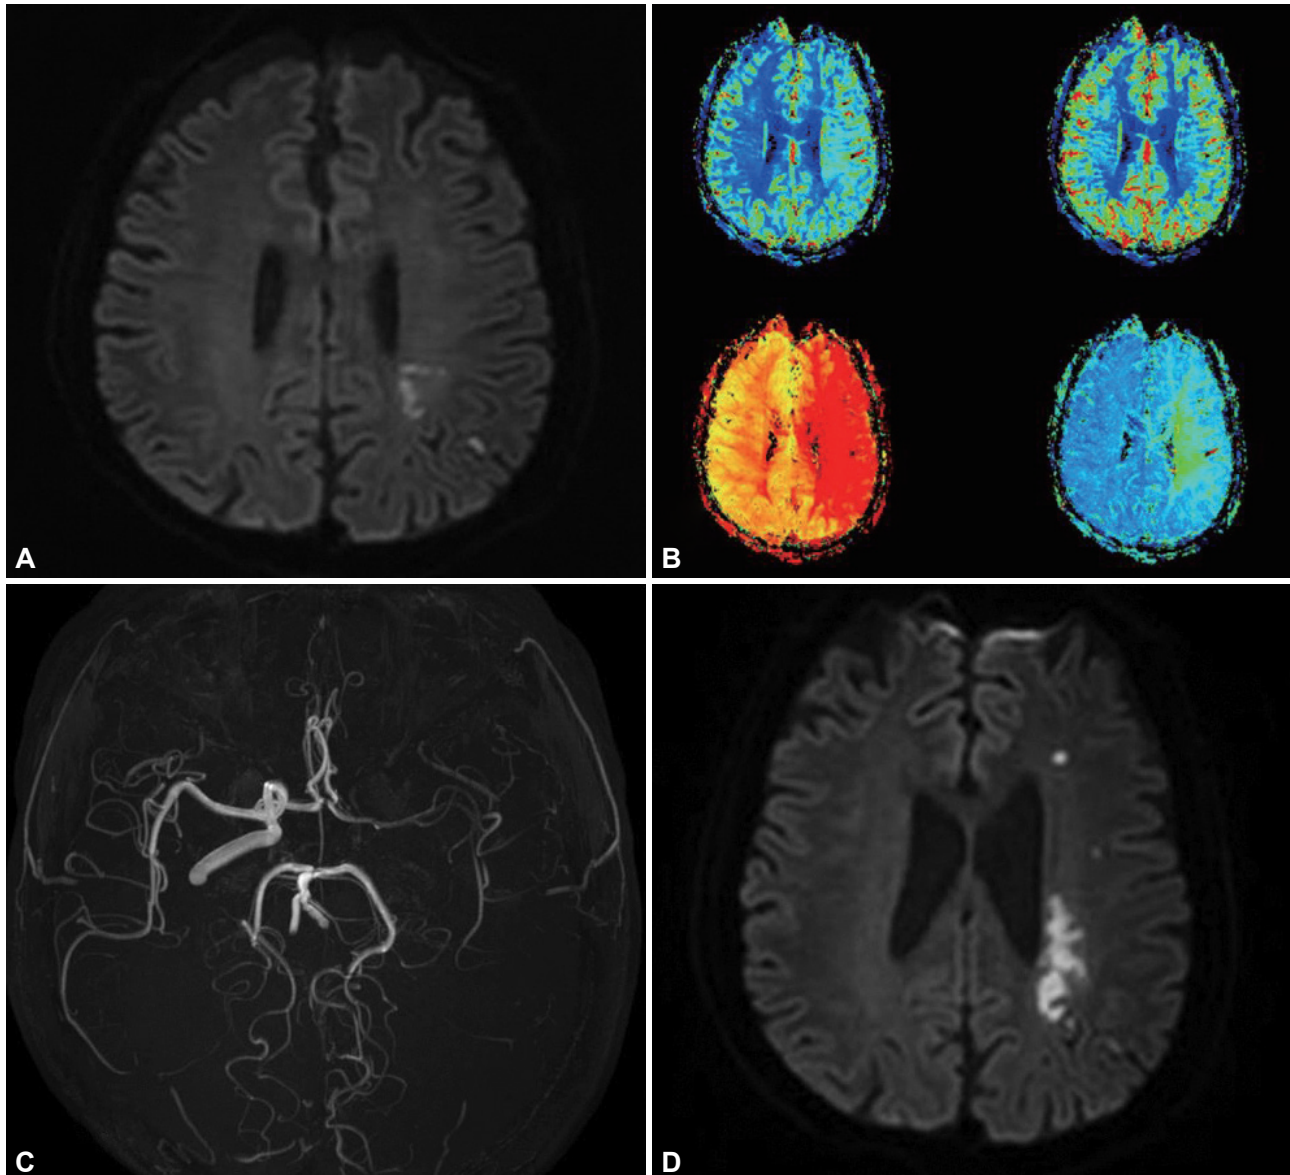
Brain magnetic resonance imaging (MRI) upon entering the emergency room, and a blood-pressure-lowering event. A: Diffusion-weighted image shows a watershed-pattern high-signal-intensity lesion in the left parietal lobe. B: Brain perfusion image shows a decrease in perfusion in the left internal carotid artery region (left upper, negative integral; right upper, index map; left lower, time to peak; right lower, mean transit time). C: The left internal carotid artery was not visible on intracranial magnetic resonance angiography. D: Diffusion-weighted image taken after the blood-pressure-lowering event shows enlargement of the lesion in the left parietal region.
